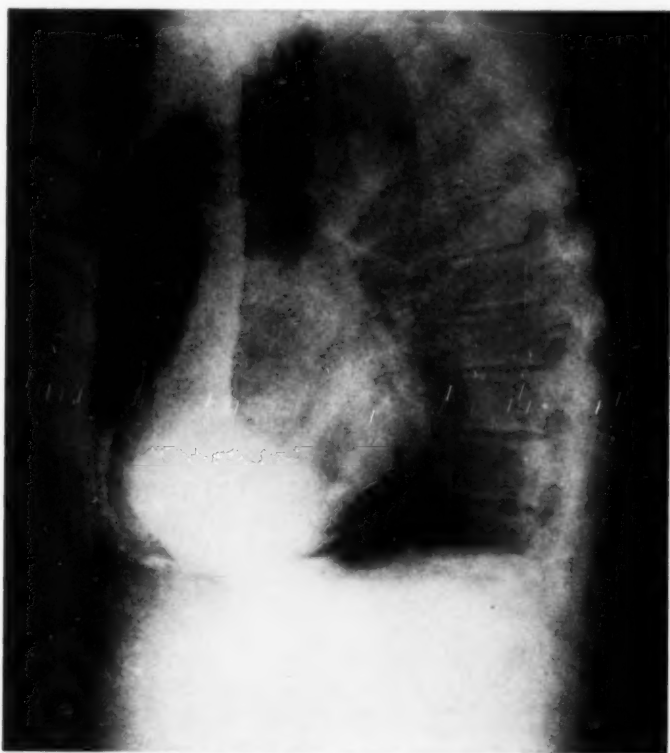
Constrictive Pericarditis*. Male, 49. Ascites, dependent edema and dyspnea, two years. Markedly elevated venous pressure, paradoxical pulse. Calcification of pericardium seen on conventional roentgenogram. *Left anterior oblique angiocardigram at two seconds*. Note opacification of dilated superior vena cava and right atrium. The right ventricular wall appears thick and contains or is surrounded by calcification.
